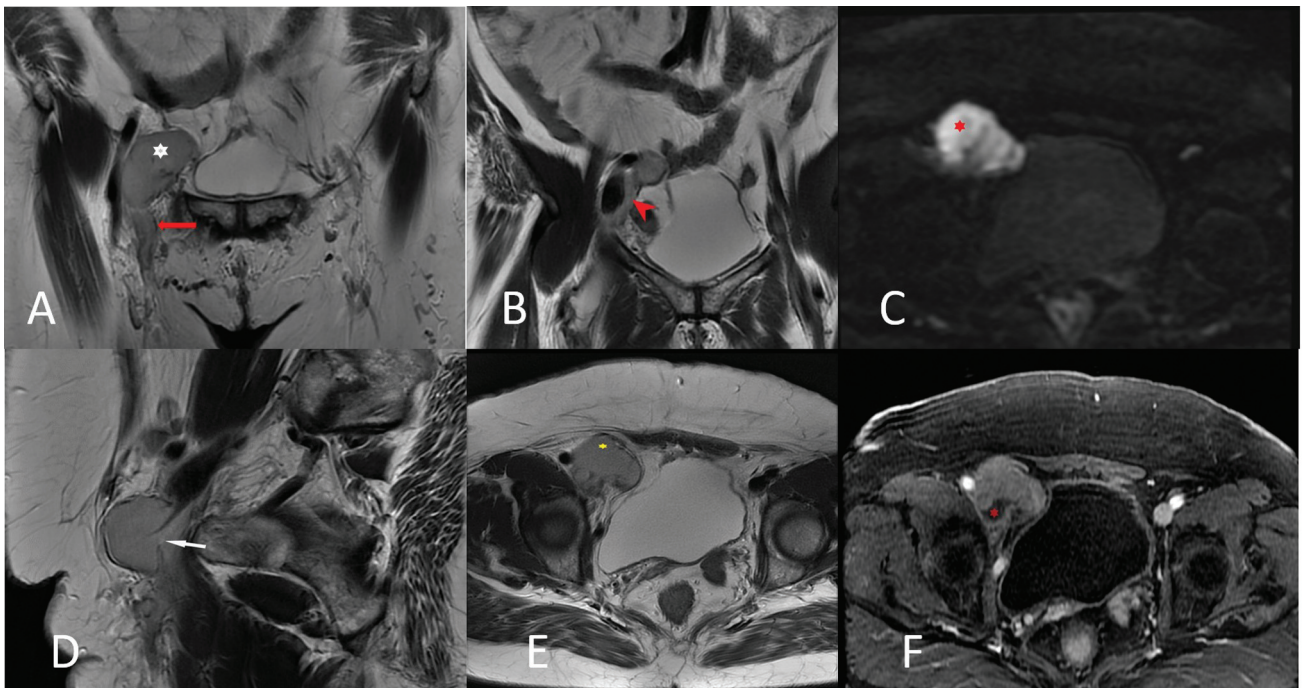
(A) Coronal T2-weighted image showing the hyperintense mass (white asterisk) which is seen extending to the great saphenous vein (red arrow). (B) The mass (red arrow) is extending intraluminally into the common femoral vein with thrombosis of the vein below the level of the lesion. (C) The lesion (red asterisk) is showing restricted diffusion. (D) T2-weighted sagittal image and axial image (E) showing the lesion breaching the anterior wall of the vein (white arrow) and extending intraluminally. (F) Contrast-enhanced T1 axial section showing the enhancing lesion with intraluminal extension and the presence of nonenhancing thrombus within the vein (red asterisk).
